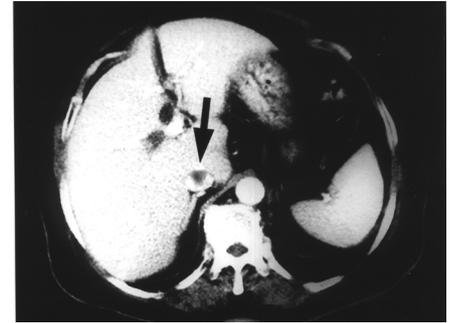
(Patient 3). CT of the upper abdomen showing "pseudothrombus" in the hepatic portion of the IVC (arrow).
